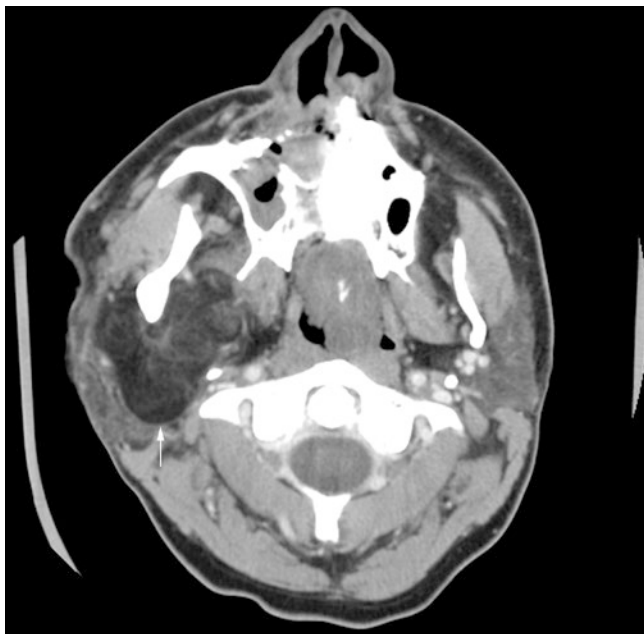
Lipoma, right neck; 29-year-old male with pain-free neck mass. Axial contrast-enhanced (soft-tissue window) CT image shows mass in parotid space with signal intensity as subcutaneous fat (*arrow*)
